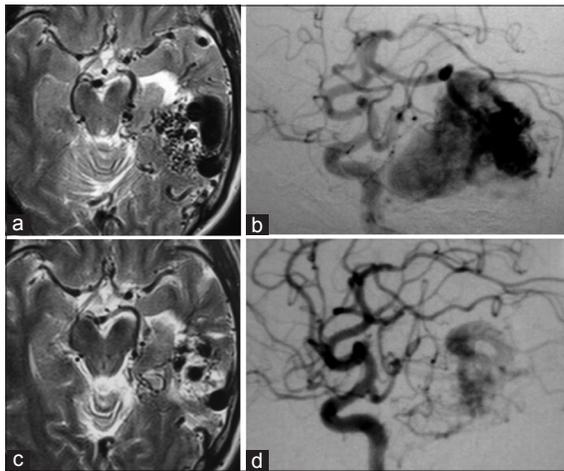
Embolization of an arteriovenous fistula before stereotactic radiosurgery (SRS). This high-flow AV fistula was associated with a left temporal arteriovenous malformation (AVM). The huge varix resulted from venous hypertension obscured the true AVM size. (a) Pre-embolization MRI. (b) Pre-embolization digital subtraction angiogram. (c) Post-embolization MRI. (d) Post-embolization DSA showing a very small residual AVM. The patient was subsequently treated with SRS
